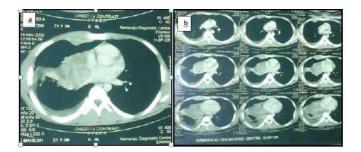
(A,B): CT chest plain and contrast showing mediastinal mass lesion with right sided pleural based lesions.
